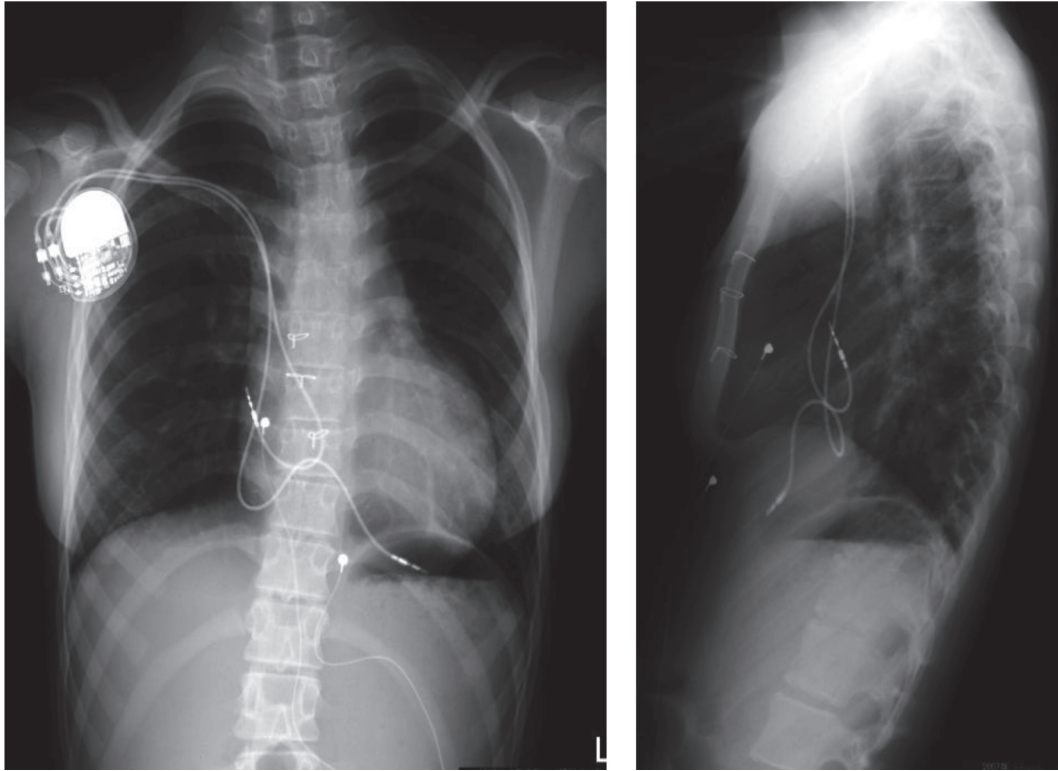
Chest X-ray just after transvenous pacemaker implantation (2007.1.25). Epicardial leads were kept for any emergency. Note that both new leads have loops long enough in her right atrium to keep up with her growth.
